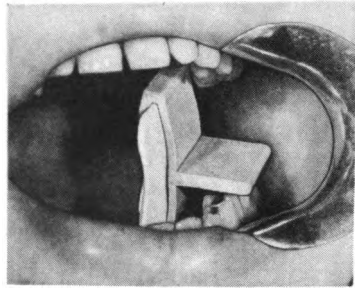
Placement of bitewing film for posterior roentgenogram.
